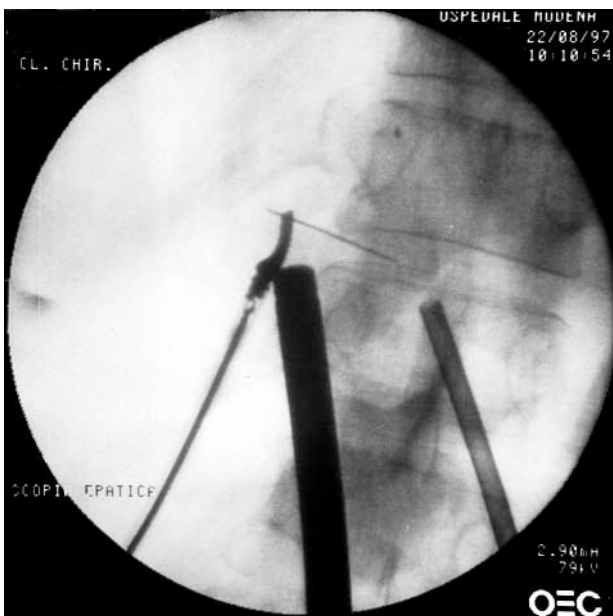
Operative radiograph examination with image enhancement. The tip of a radio-opaque forceps is being used as a point of reference in dissecting the parenchyma to reach the needle.
